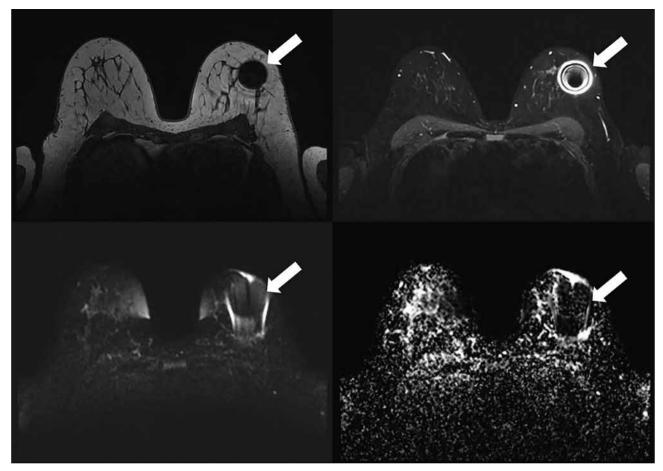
Magnetic resonance images of a 40-year-old woman with biopsy-proven left breast malignancy and prior Magseed insertion, for treatment response after neoadjuvant chemotherapy. Most of the left breast was obscured due to significant metallic artifact (arrows) produced by the Magseed.
